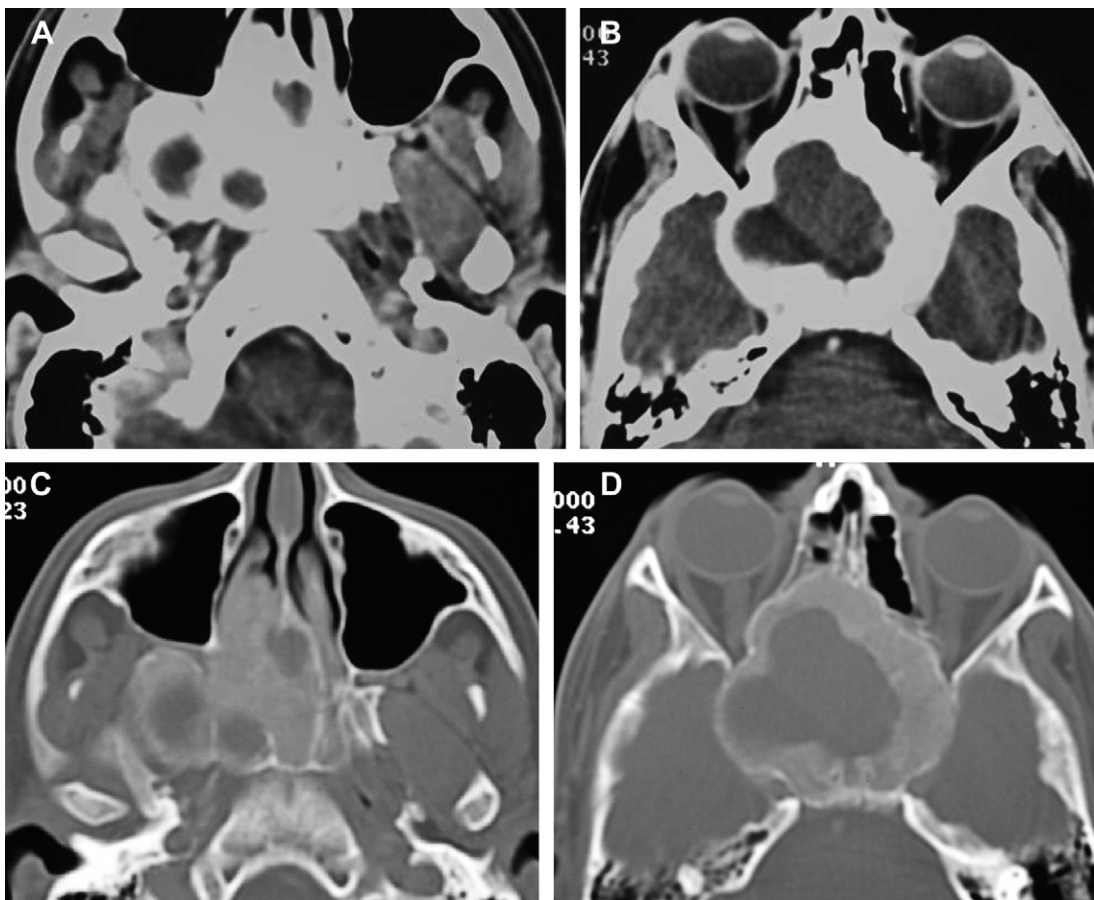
Axial CT images on soft tissue (A and B) and bone window (C and D), show an expansile lesion centered in the sphenoid body, which obliterates the sphenoid sinus extends inferiorly into the pterygoid plates and anteriorly into the posterior nasal septum and nasal turbinates. The lesion is homogeneously hypodense, surrounded by a thick rim of sclerotic bone with a ground-glass pattern excluding sphenoid mucocele as a possible diagnosis (ossifying fibroma).
